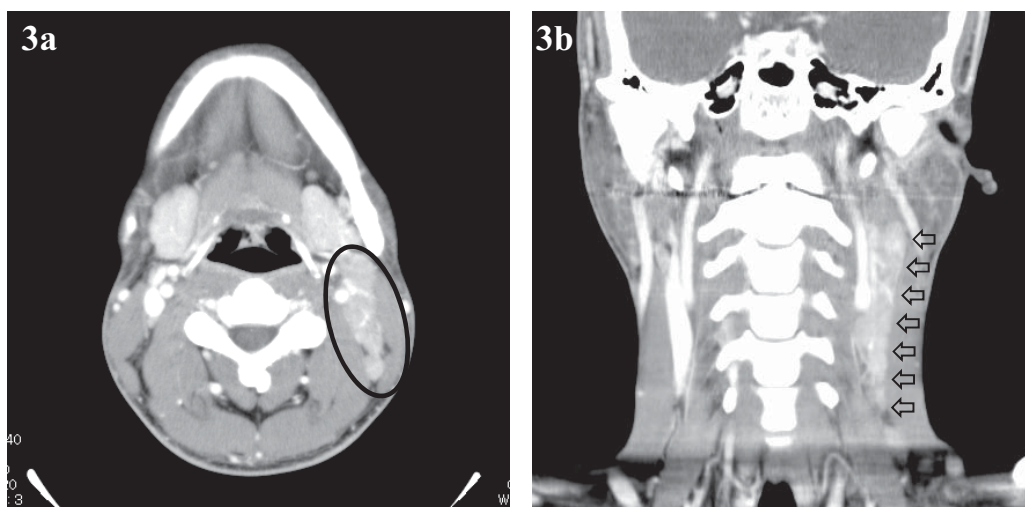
Computed tomography. Swollen lymph nodes lesions are observed at the left side of the neck. 27-year-old male. (3a); axial section (circle), (3b); coronal section (arrows).
